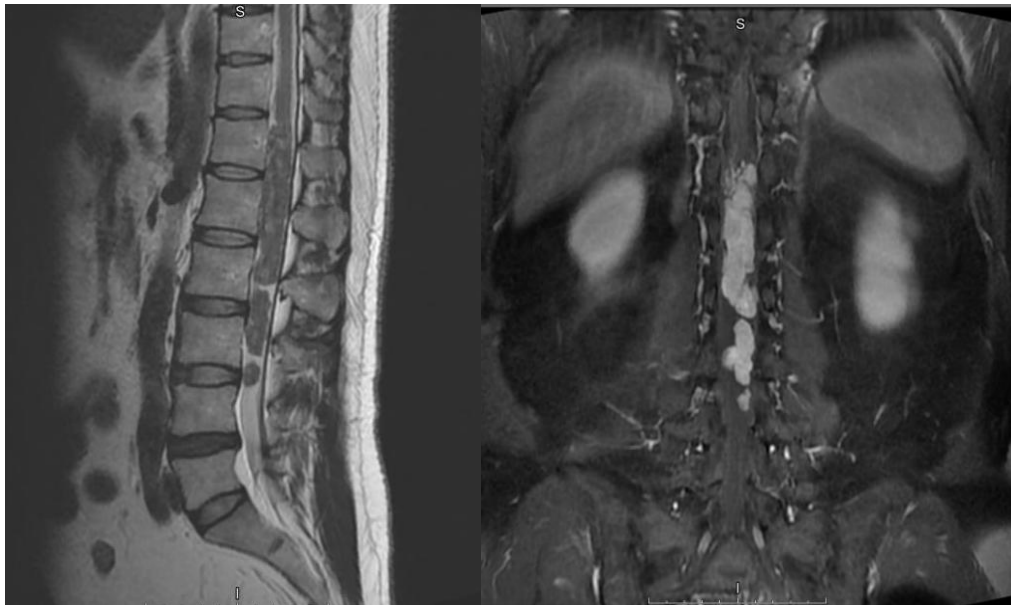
MRI data intradural extramedullary spinal cord tumor at the level of VTh12, L1-2-3-4 vertebrae
